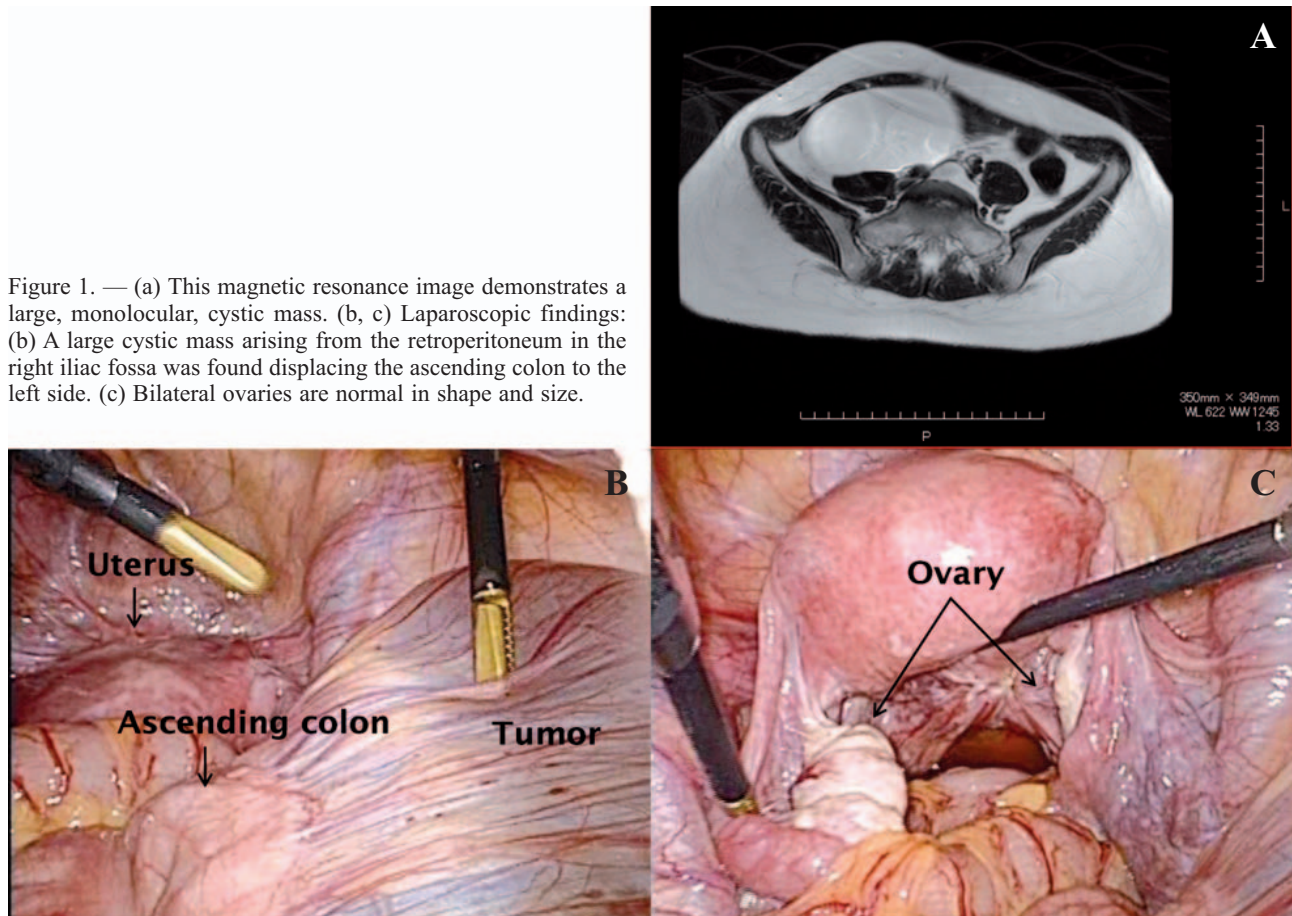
(a) This magnetic resonance image demonstrates a large, monolocular, cystic mass. (b, c) Laparoscopic findings: (b) A large cystic mass arising from the retroperitoneum in the right iliac fossa was found displacing the ascending colon to the left side. (c) Bilateral ovaries are normal in shape and size.
